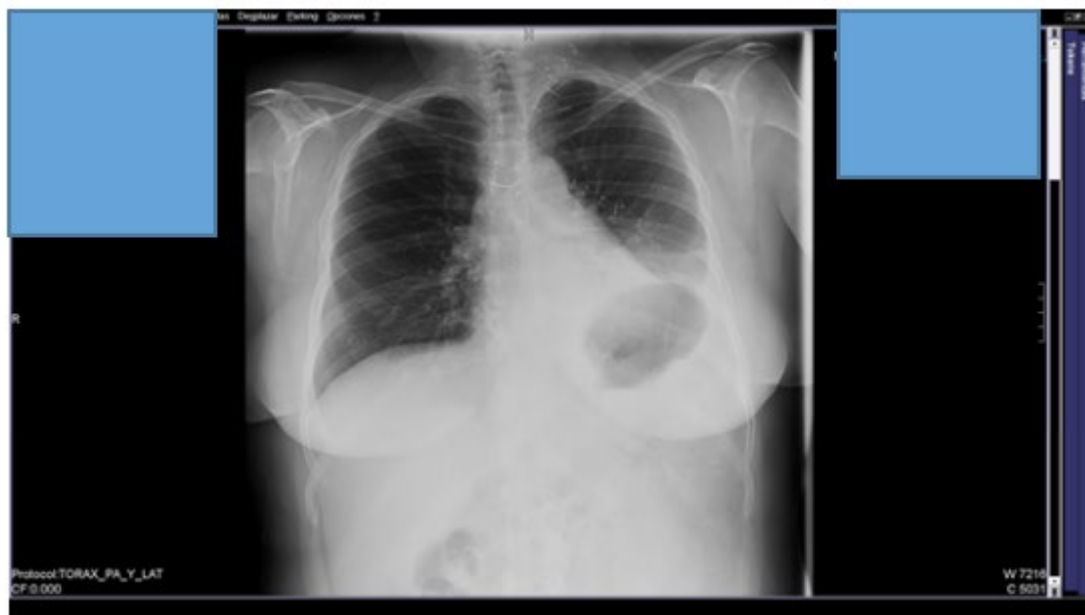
Chest X-ray 3 days' post-surgery. Left hemidiaphragm elevation.
